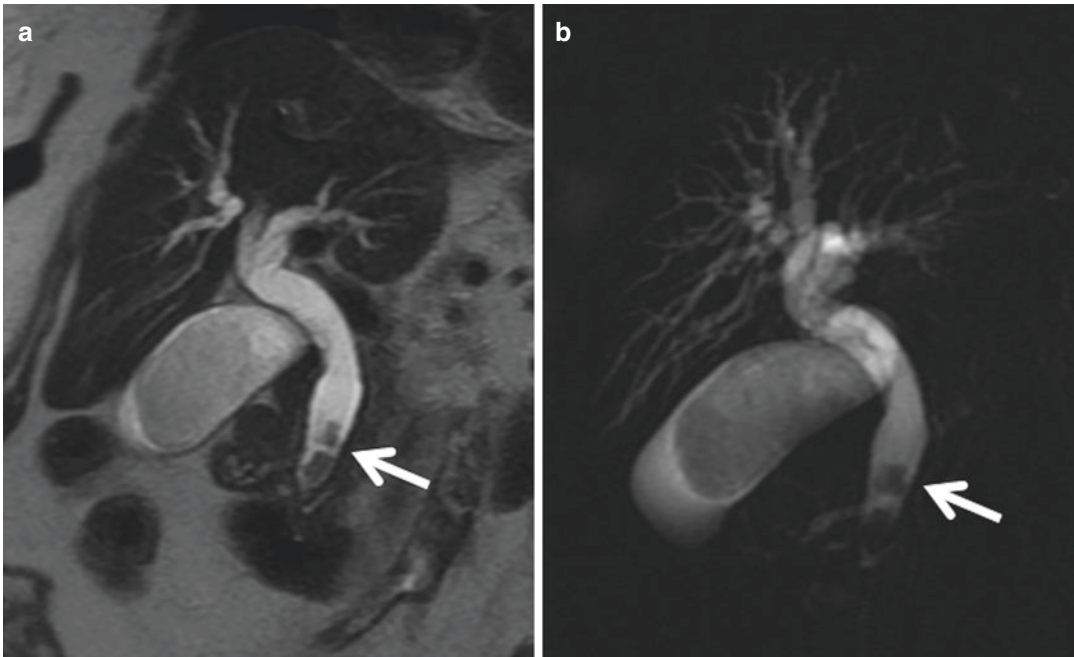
Two hypointense biliary stones (*arrows*) in the distal part of the CBD on (a) coronal T2-weighted image and on (b) 2D-MRCP coronal oblique image
